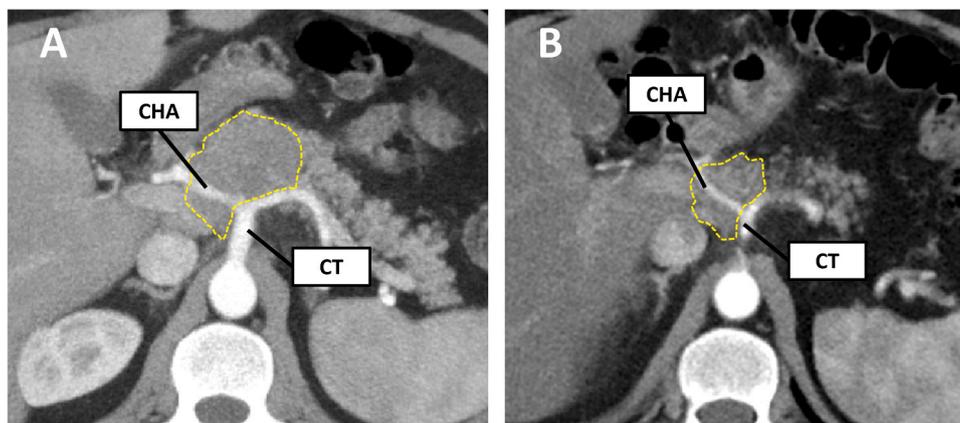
Response to neoadjuvant therapy. (A) reveals a locally advanced PDAC (dashed line) with common hepatic artery (CHA) encasement up to the celiac trunk bifurcation (CT). After the completion of neoadjuvant chemotherapy, the tumor had reduced in size (B, dashed line), but maintained a long encasement of the CHA. The patient underwent surgery, with an R0 resection.
